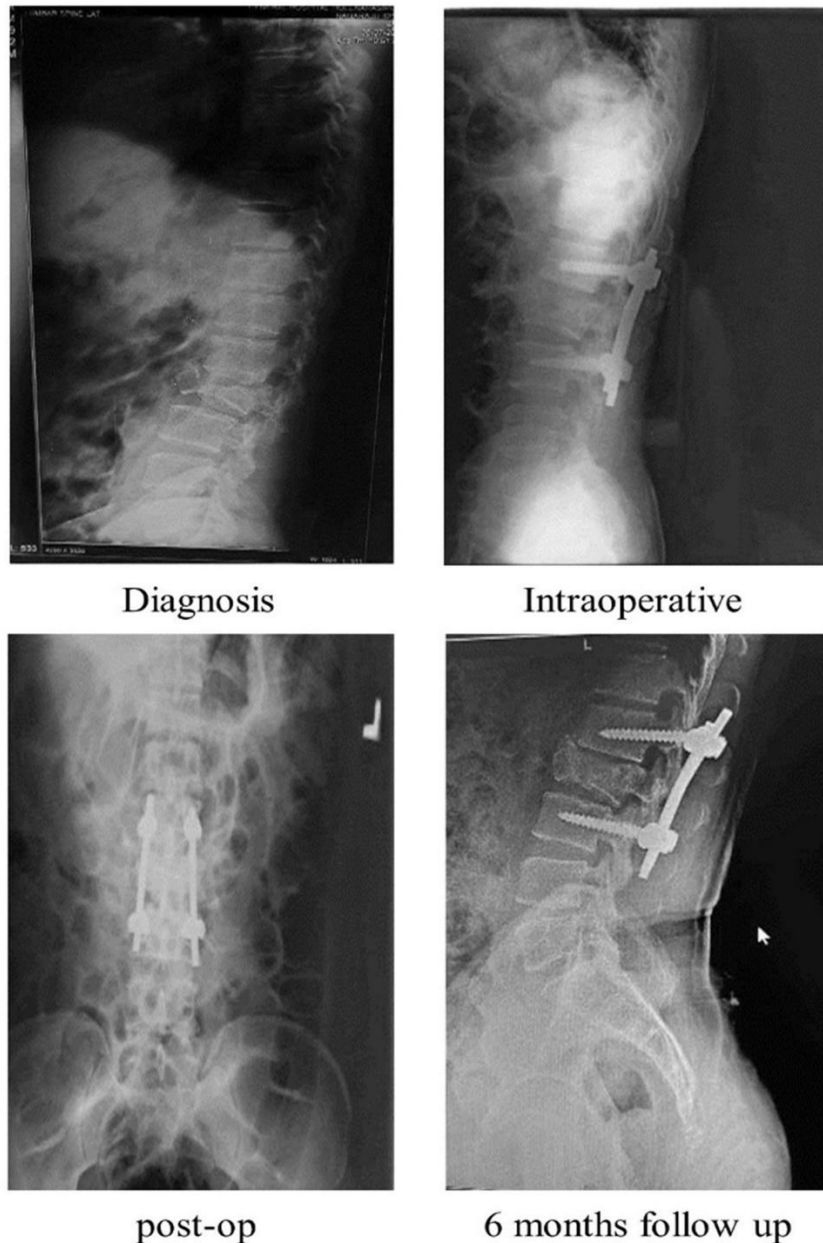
Representative MRI findings of a 65-year-old male at different stages.
